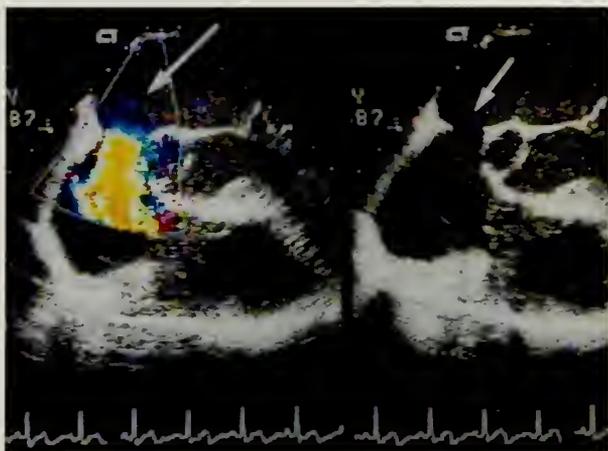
Right, A large secundum-type interatrial septal defect is visualized (arrow) on transesophageal echocardiography. Left, Color-flow Doppler demonstrates left-to-right shunting across an atrial septal defect (arrow).
